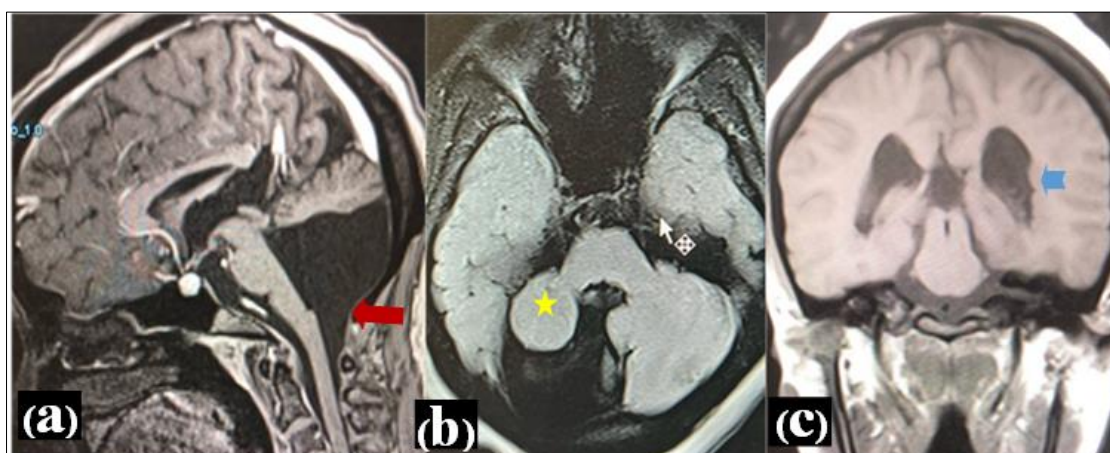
Magnetic resonance images in the case of NMD. (a) Sagittal T1 (b), FLAIR (c), and Coronal T1 showing structural anomalies of the brain
